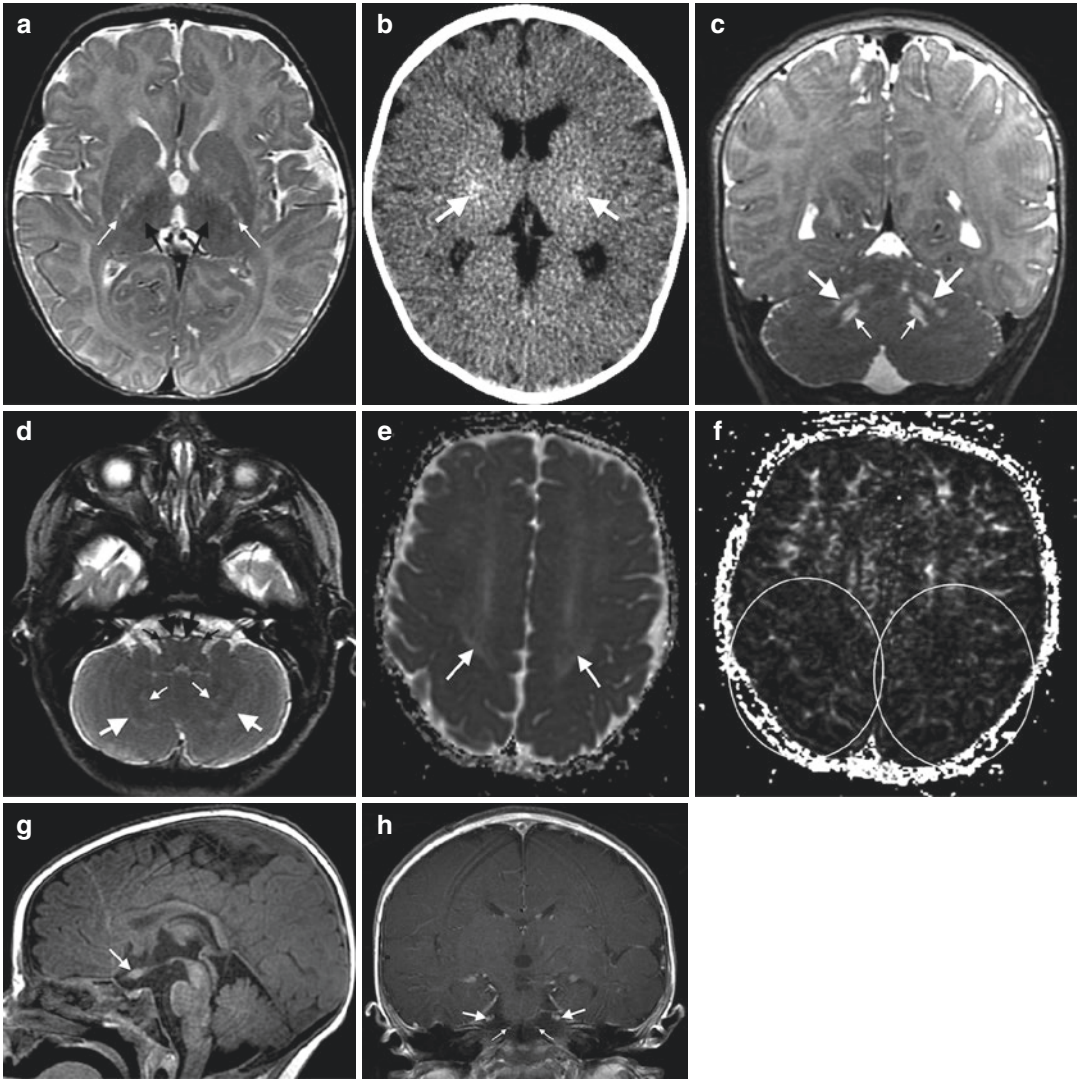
4-month-old male with Krabbe's disease. Axial T2WI (TR/TE ms, 3375/103) (a) and axial CT (b) through the cerebral deep gray nuclei demonstrate abnormal mineralization of the thalami, hypointense on T2WI (*black arrows, a*) and hyperdense on CT (*arrows, b*). The PLIC is abnormally hyperintense (*white arrows, a*). Coronal T2WI (TR/TE ms, 3500/90) (c) and axial T2WI (TR/TE ms, 3375/103) (d) show hyperintense deep cerebral white matter (*large white arrows, c and d*) and dentate nuclear hila (*small white arrows, c and d*), marginating the dentate nuclei proper. The medullary pyramids (*large*
